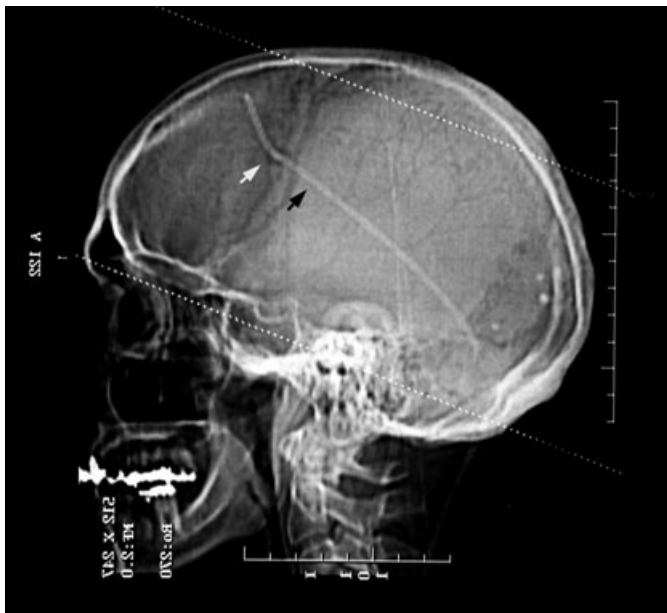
Antemortem CT scan of L.K.; white arrow indicates location of surgical trephination, black arrow indicates peritoneal drainage shunt exiting cranium inferior-posteriorly.
